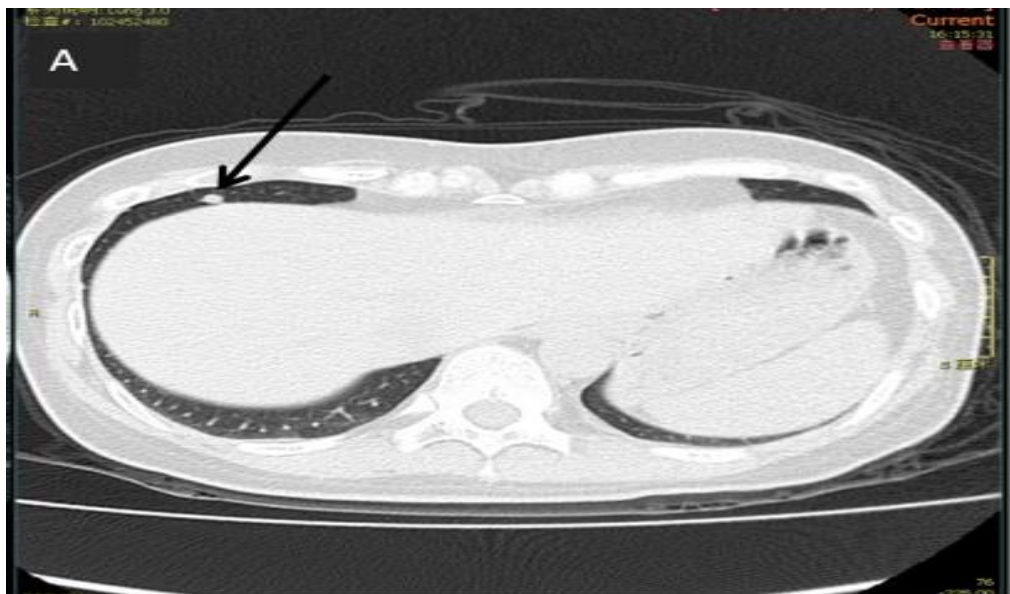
Chest CT (before chemotherapy)
